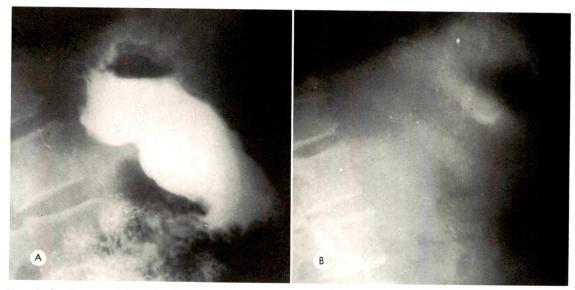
Carcinoma of the tail of the pancreas. (A) Left lateral roentgenogram shows no retrogastric space enlargement. (B) Thirty minutes later, with the stomach empty, the retrogastric space is markedly enlarged. Barium, due to wrap-around effect, may obscure large tumors. The importance of a detailed evaluation of gas shadows is demonstrated.
